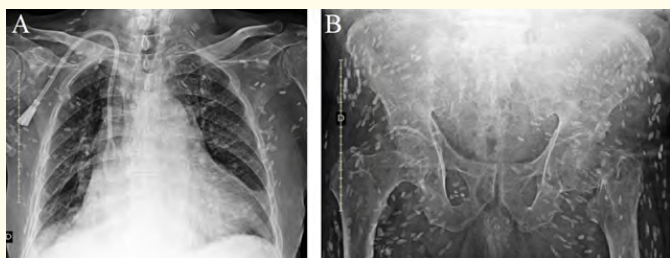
In A, anteroposterior thorax x-ray demonstrating multiple calcifications throughout the thoracic musculature; enlargement of the heart, pulmonary opacity adjacent to the cardiac atria, and double lumen catheter in his superior vena cava. In B, anteroposterior pelvis x-ray demonstrating multiple calcifications throughout the thoracic musculature and a left neck femoral fracture.
